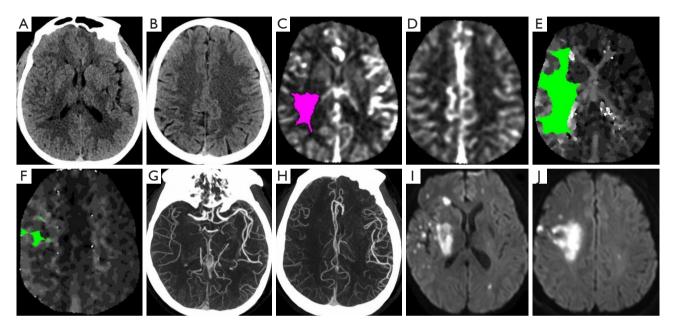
A 54-year-old male, WUS patient admitted with last seen well 6 h and 24 min and right MCA occlusion. Baseline (A,B) NCCT ASPECTS shows 9, (C,D) infarct volume 15 mL, (E,F) penumbra volume 86 mL, (G,H) good collateral (Tan score 2). Post EVT patient achieved good recanalization (TICI 3) with (I,J) 24-h post-reperfusion infarct volume is 65 mL. WUS, wake-up stroke; MCA, middle cerebral artery; NCCT, non-contrast CT; ASPECTS, alberta stroke program early CT score; EVT, endovascular thrombectomy; TICI, thrombolysis in cerebral infarction.
